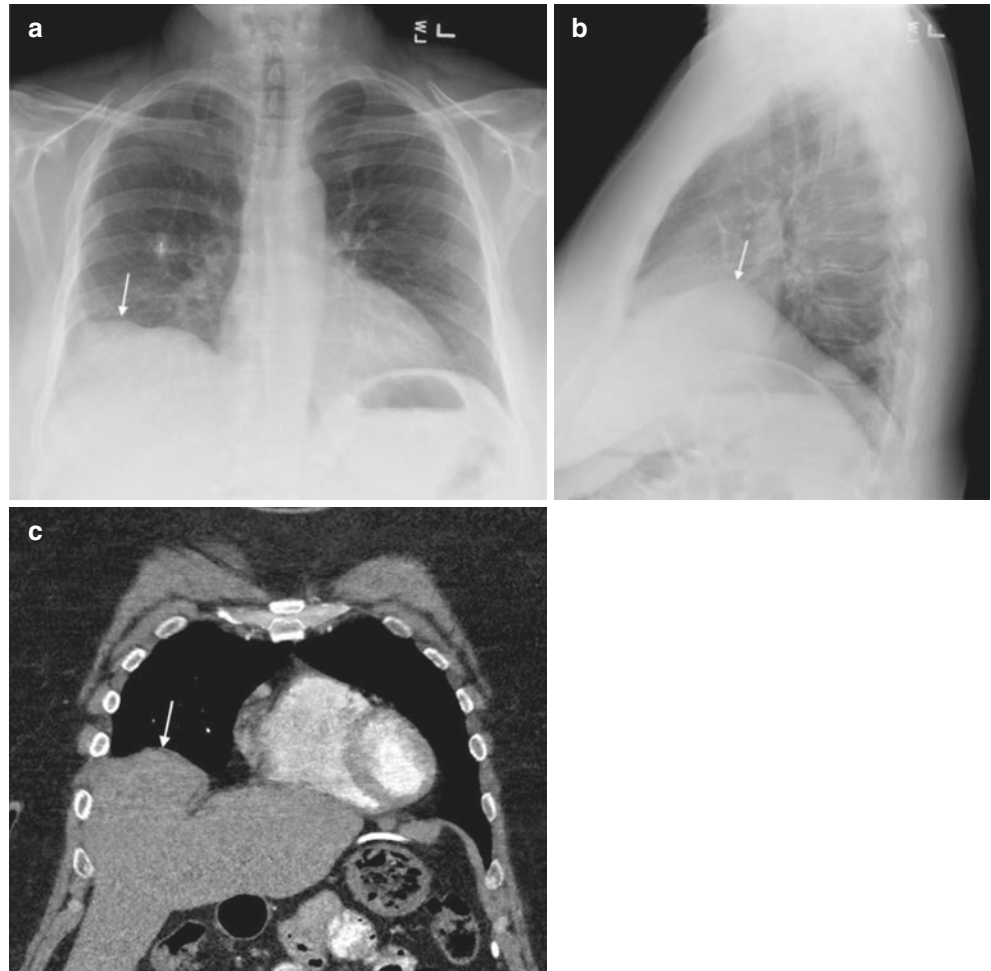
Diaphragmatic eventration (a-c). (a) Frontal and lateral (b) chest radiographs show a focal bulge in the lateral (arrow in (a)) and anterior (arrow in (b)) right hemidiaphragm. (c) Coronal contrast-enhanced CT through the anterior chest at mediastinal windows show the liver projecting into the lower right chest due to eventration of the lateral right hemidiaphragm (arrow)
